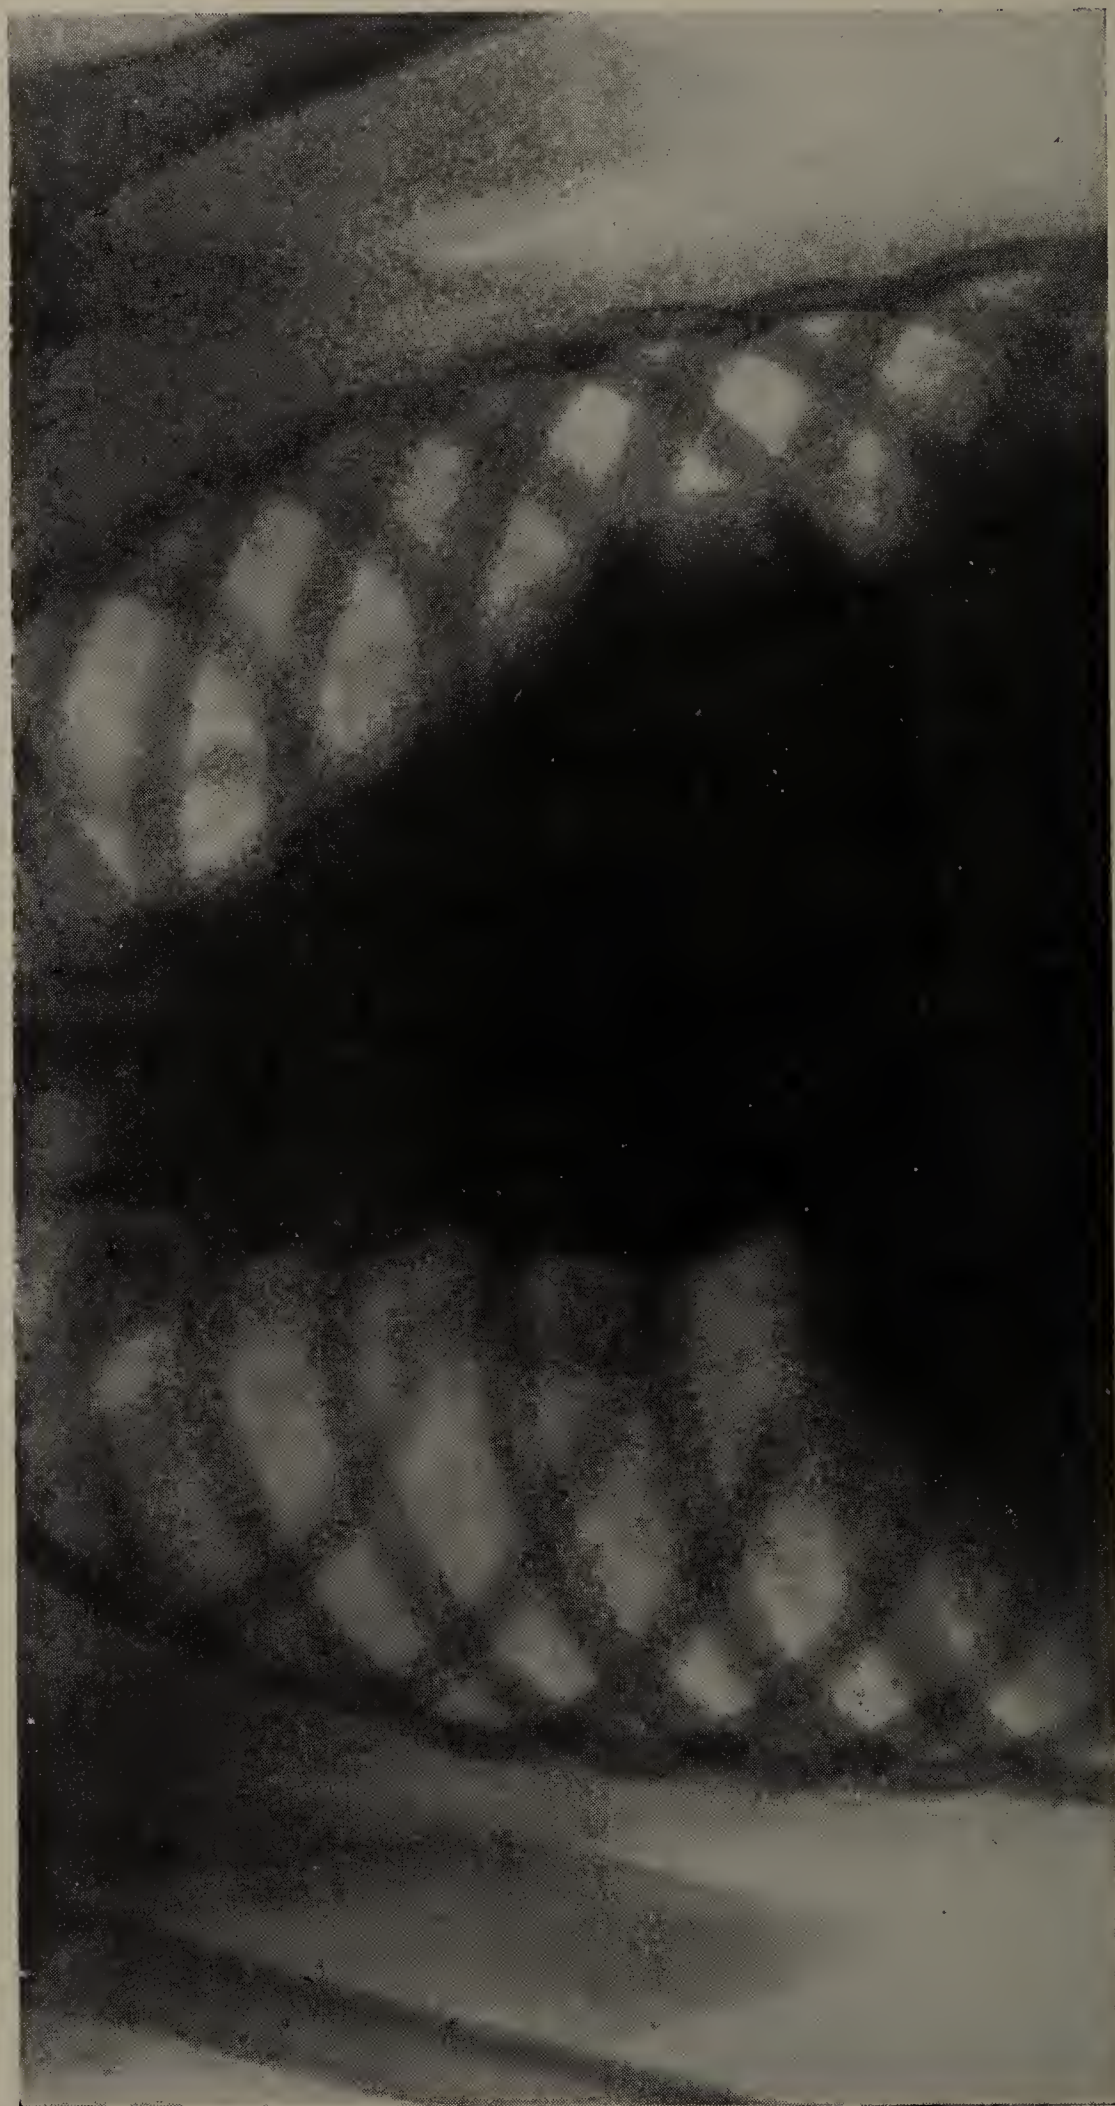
Cut of radiograph showing clavicles and front and back part of the ribs, with lattice-work effect.
